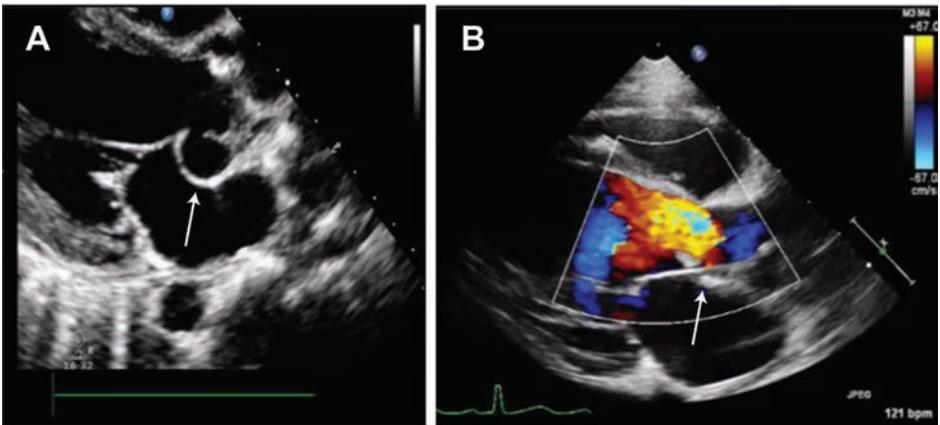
Parasternal long axis view (2D and color Doppler) demonstrating a periaortic root abscess. (arrow) with severe AI. Images courtesy of Dr. Josh Kailin, www.pedecho.org.
